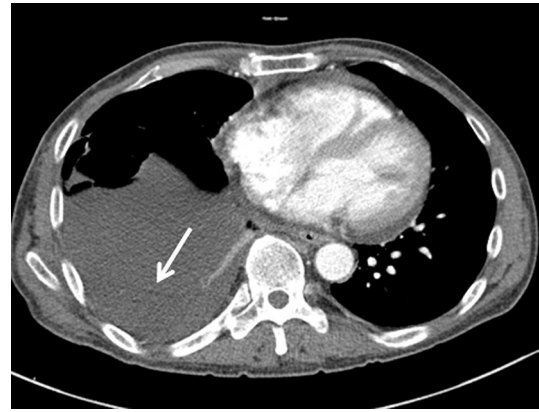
Chylothorax in a 56-year-old man treated with right upper lobectomy and resection of 1-to-4th ribs for adenocarcinoma. Axial CT image shows a large fluid collection with focal low attenuation in the right hemithorax (arrow). The focal low attenuating area reveals -4.2 H.U. and pleural fluid triglyceride level was 496 mg/dL
